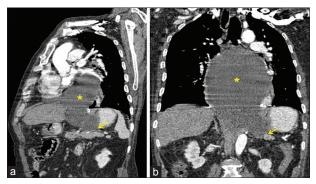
Reformatted coronal image (a) and true coronal sections (b) of contrast enhanced multidetector computed tomography scan of the chest showing collection (star) extending up to pancreatic tail (arrow)
